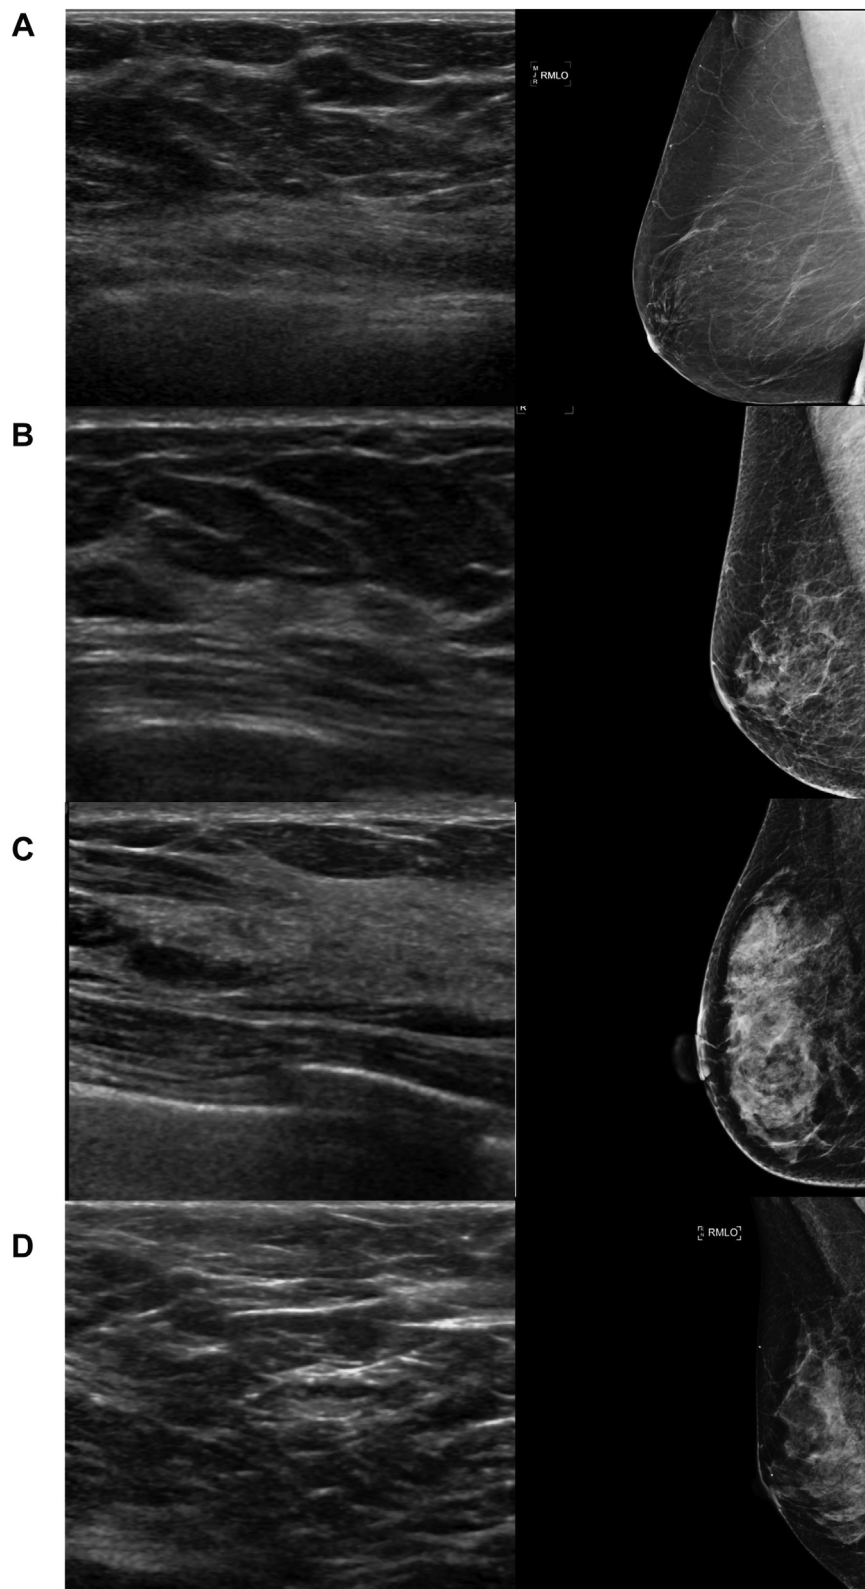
Example clinical breast ultrasound (left) and right mediolateral oblique digital 2D mammography (right) images, selected from the dataset included in this work. Image sets are labeled with their BI-RADS breast density category. Images have been cropped for ease of display.
